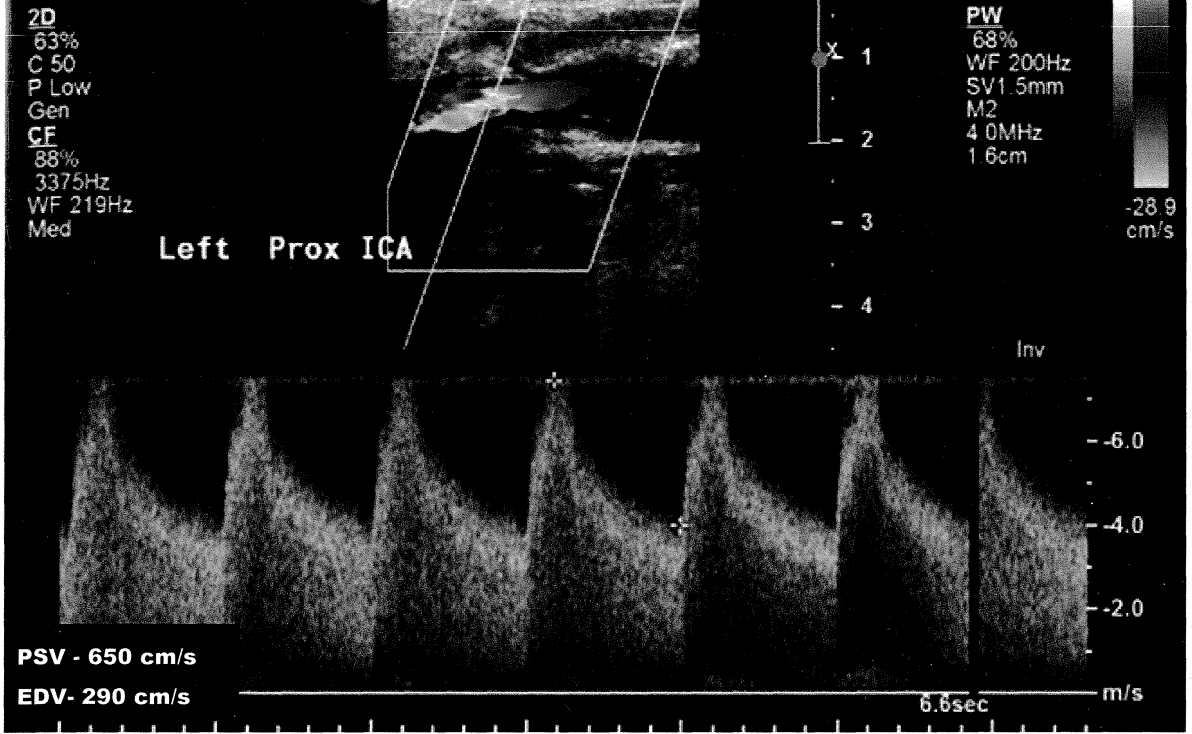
1. Color-assisted carotid duplex ultrasonography demonstrating a severe left internal carotid artery stenosis. Note the marked elevation in peak systolic velocity (650 cm/s) and end-diastolic velocity(290 cm/s).
